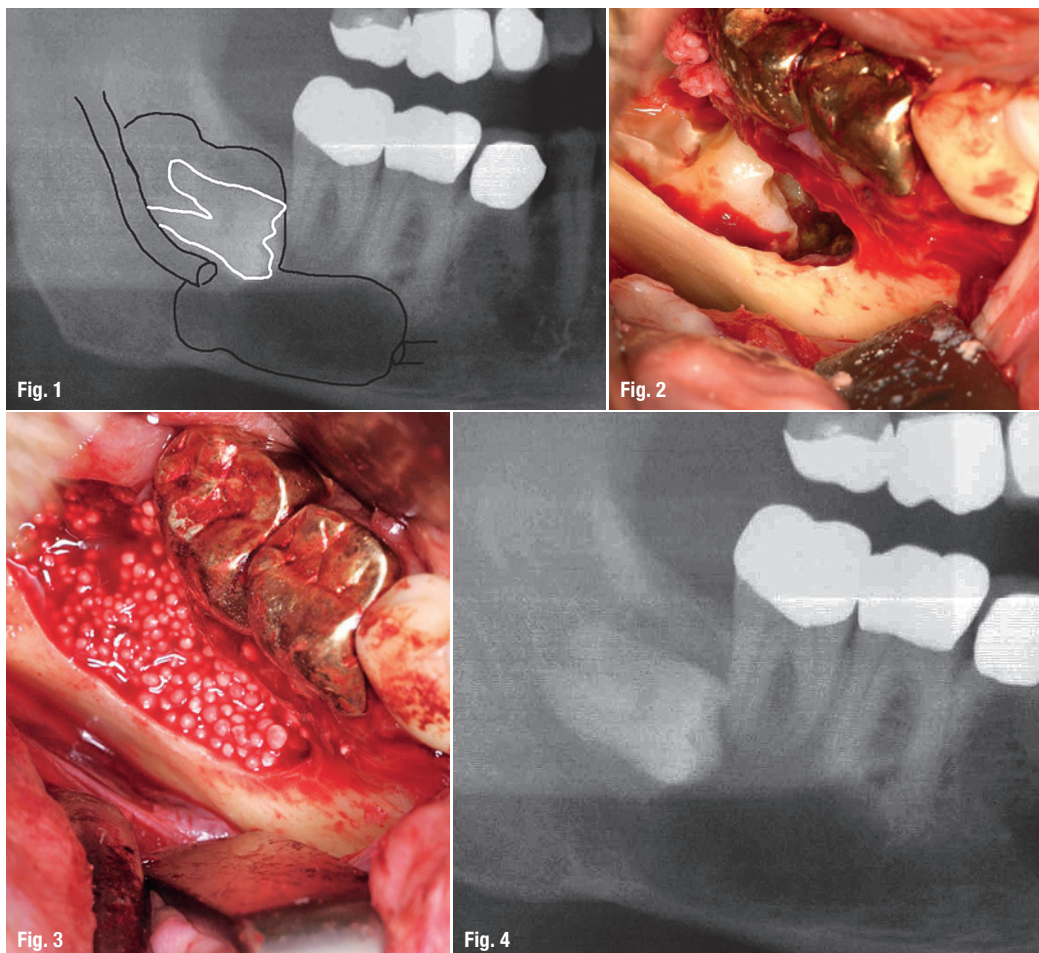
Pre-op X-ray in right mandibular.
